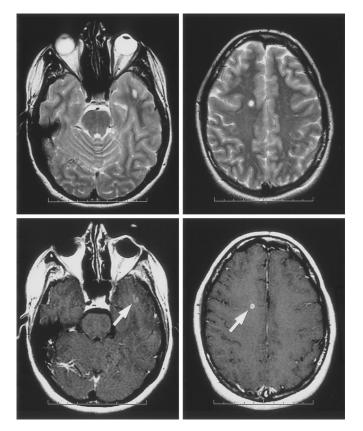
MRI scans performed 3.5 months after presentation and 6 weeks after discontinuing etanercept. Axial T2weighted images show new lesions in the left temporal lobe and right frontal lobe (top row). Axial T1-weighted images obtained after contrast was given shows enhancement of these areas (bottom row).
